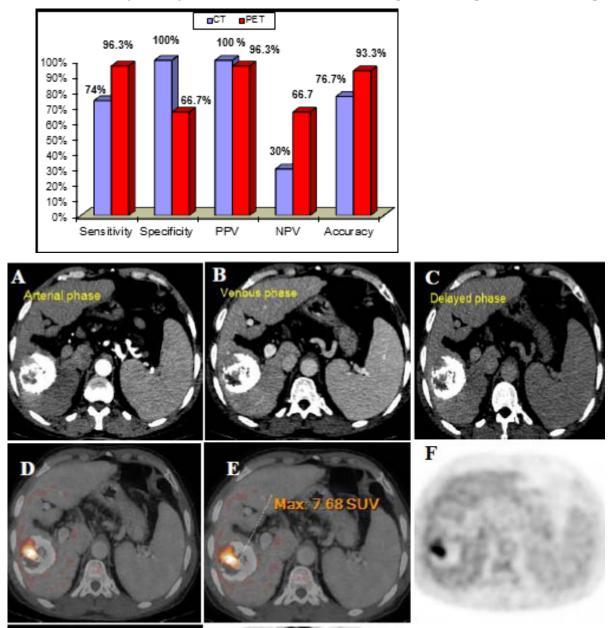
Fifty seven years old male patient, presented with history of chemoembolization for hepatic focal lesion and persistent elevated alpha fetoprotein level. A, B, C CECT phases show dispersed lipiodol hindering accurate assessment. D and E fused PET/CT image showing hyper metabolic activity at right superior margin of the chemo-emoblized lesion. F Axial CTAC image showing focal FDG uptake
